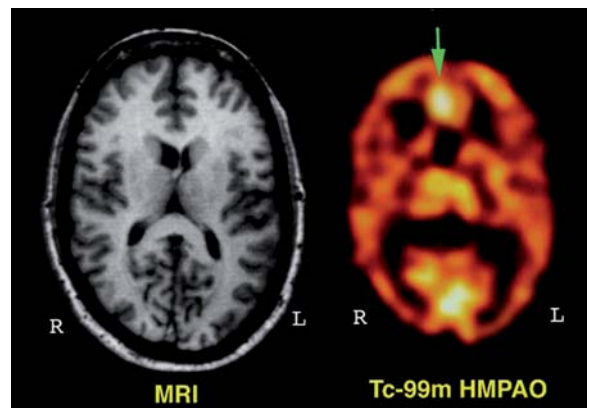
Coronal images from MRI (*left*), ictal Tc-99m-HMPAO SPECT (*middle*), and interictal F-18-FDG PET scan (*right*) of a 42-year-old female with intractable seizures. *Left* The MRI scan is normal. *Middle* The ictal Tc-99m-HMPAO brain SPECT scan showed a focal area of significant hyperemia in the right mesial frontal lobe (*arrow*).
